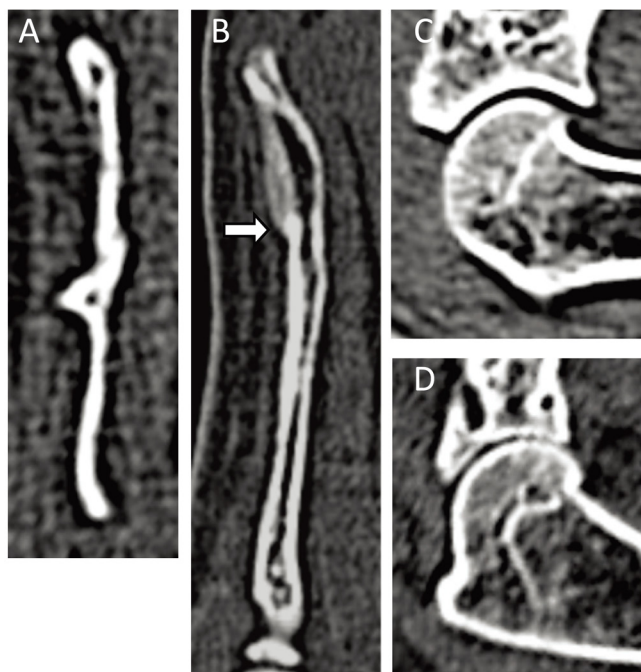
(A) No local recurrence is observed on the short axis view of the scapula on computed tomography; (B) Bony union of the scapula is observed on the long axis view; (C) The articular surface of the shoulder joint before surgery; (D) The articular surface of the shoulder joint after surgery. Bony union between initial scapula and frozen autograft is established without local recurrence, and the postoperative articular surface of the shoulder joint appears slightly rougher.
